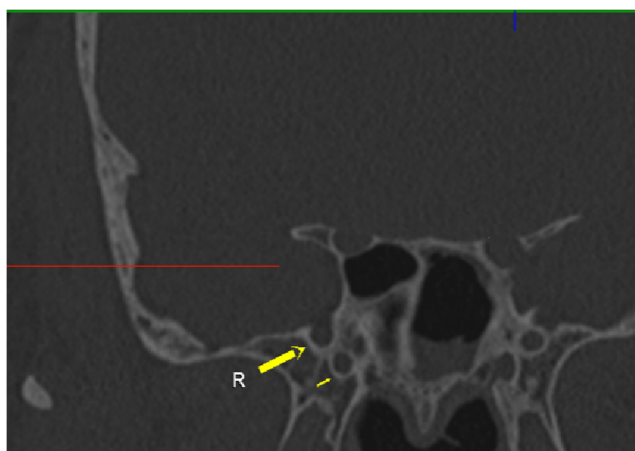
Coronal CT with the bone window at the foramen rotundum (R) level showing its relationship with the vidian canal (short arrow) in the sphenoid body
